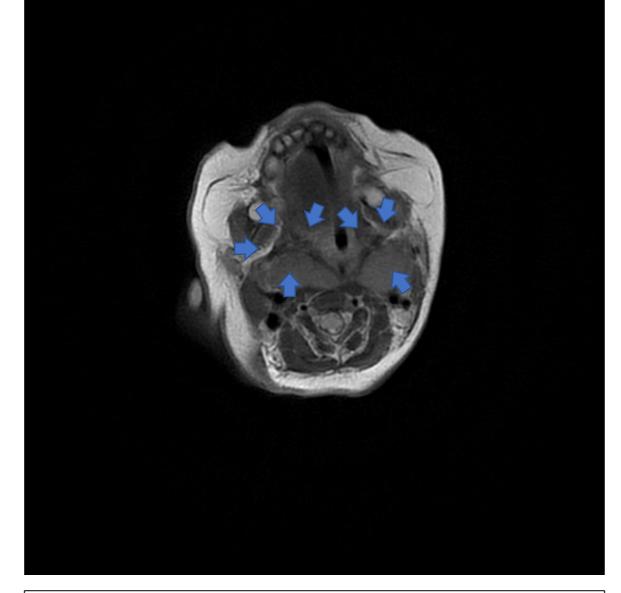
Enlargement of thyroid with retropharyngeal gland extension of both lobes (arrows *indicate the thyroid enlargement)* (axial MRI image)
